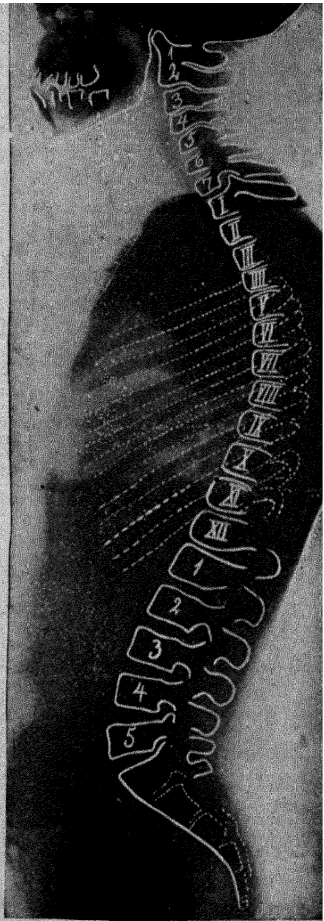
X-ray photo of the round-backed boy in Fig. 31. Here the lordosis is almost confined to a sharp bend between the fourth and fifth lumbar vertebra and the sacrum.
